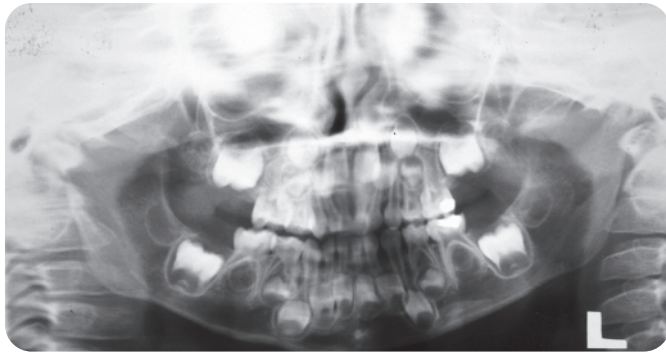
Pre-op panoramic radiograph
